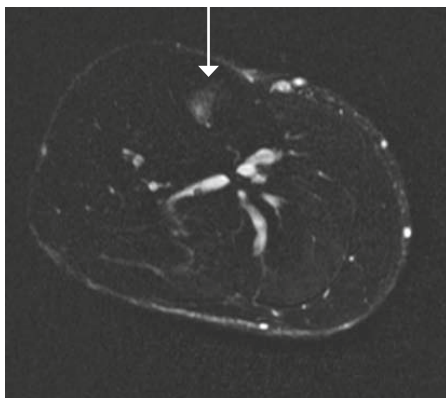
MRI of a 49 year old male with psoriatic arthritis. On the MRI the T2 weighted, fat suppressed axial image of the right leg shows bone marrow oedema in the tibia (arrow).
